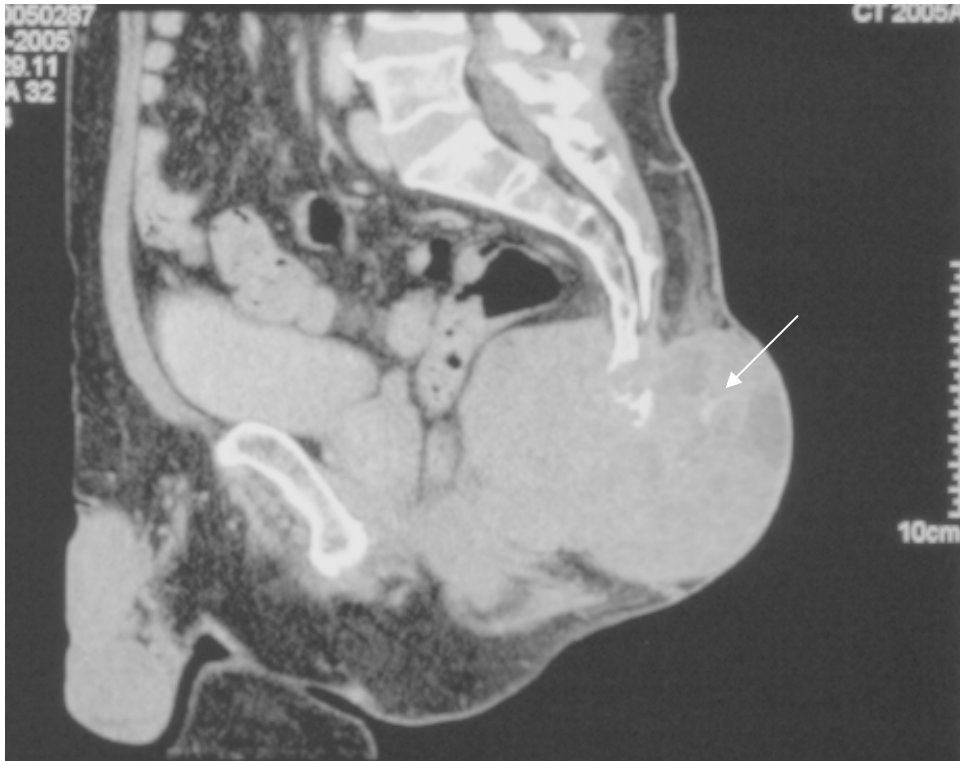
CT-image of a 62-year-old male. The sacro-coccygeal chordoma (arrow) presented with an extension of 12,7 (sagittal) x 10 (cranio-caudal) x 9,1 (transversal) cm. The calculated tumour volume resulted in 577,8 cm³.
